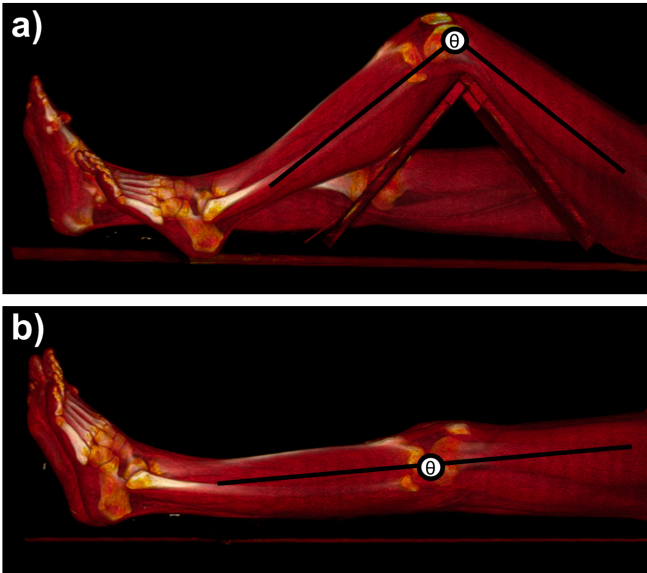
CTA acquisition protocol with a) bent- and b) straight-leg configuration.
